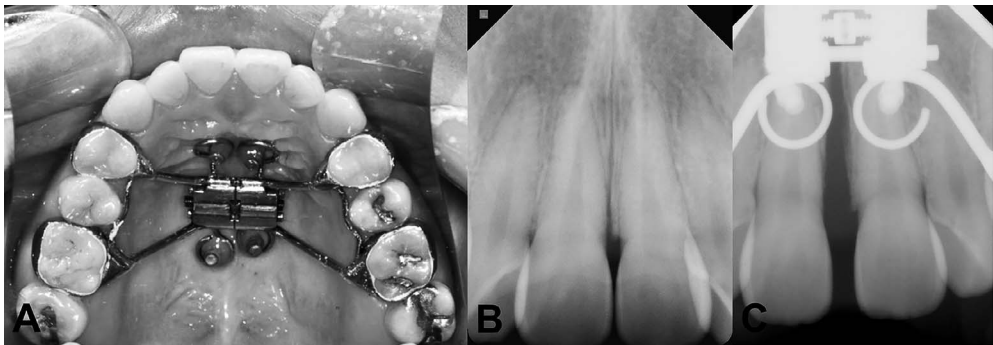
Fixation of the miniscrew-assisted rapid maxillary expansion (MARME) device and periapical views before and after expansion. (A) A MARME appliance. (B) Before expansion. (C) After 2 weeks of expansion, a diastema caused by splitting of the midpalatal suture can be observed.
